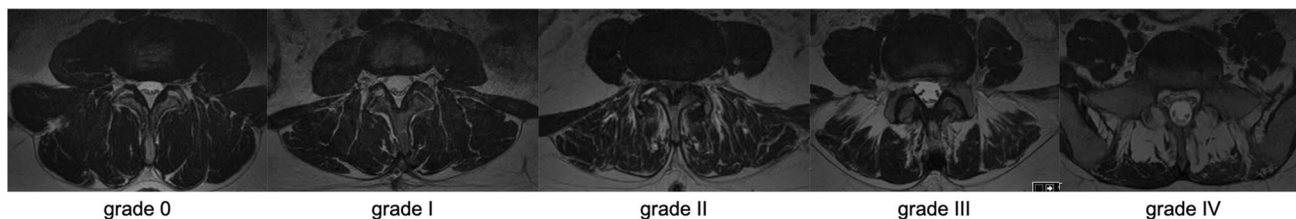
Goutallier classification on axial T2-weighted images defined as follows: grade 0, no intramuscular fat; grade I, some fatty streaks present; grade II, fat evident, but less than muscle tissue; grade III, amounts of fat equal to amount of muscle; grade IV, more fat than muscle tissue
